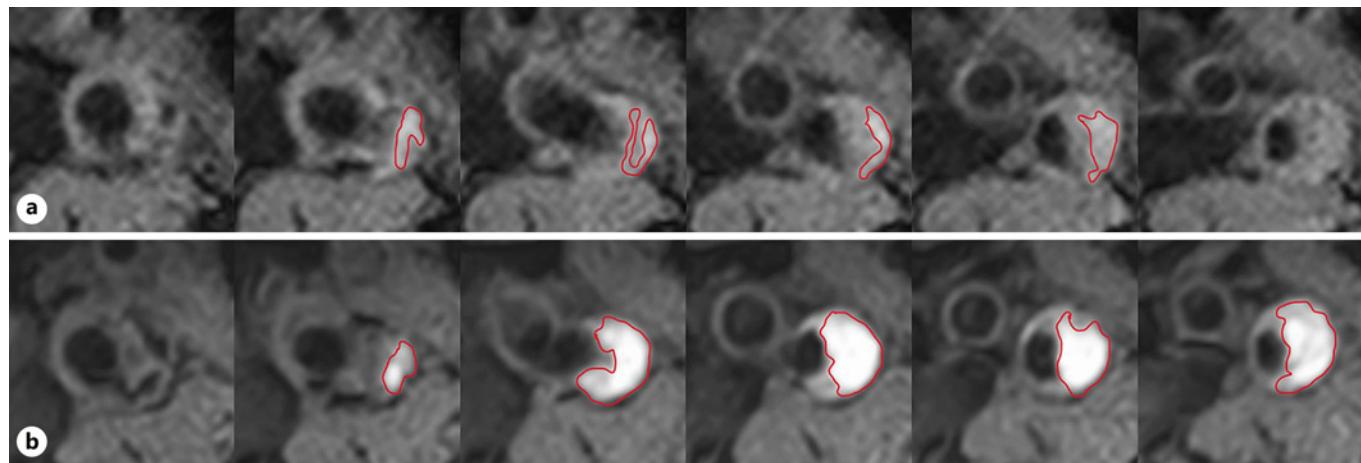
IPH progression after two 2-year follow-up in a new antiplatelet user. 3D T1-weighted inversion recovery turbo field echo images of carotid atherosclerotic plaque with IPH at the baseline (a) and follow-up (b). IPH volume (red contours) increased from 121.0 mm^3 at the baseline to 250.6 mm^3 after 2 years of follow-up (107% increase). IPH, intraplaque hemorrhage.
